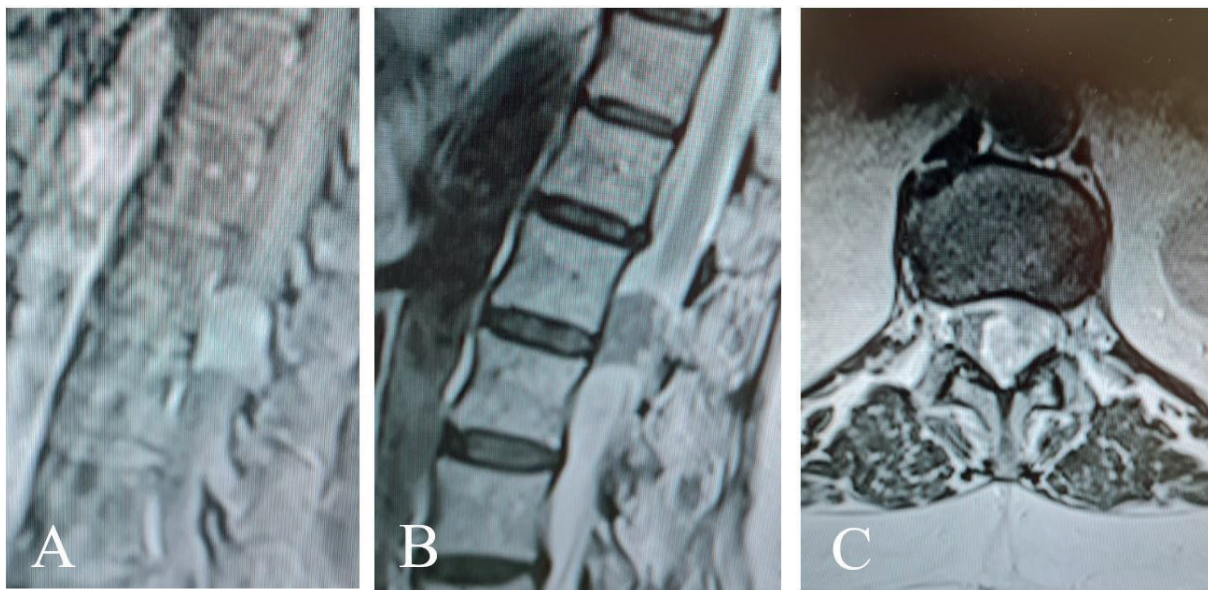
Preoperative MR images of a patient with thoracic schwannoma A. Sagittal Postcontrast T1 B. Sagittal T2 C. Axial T2
